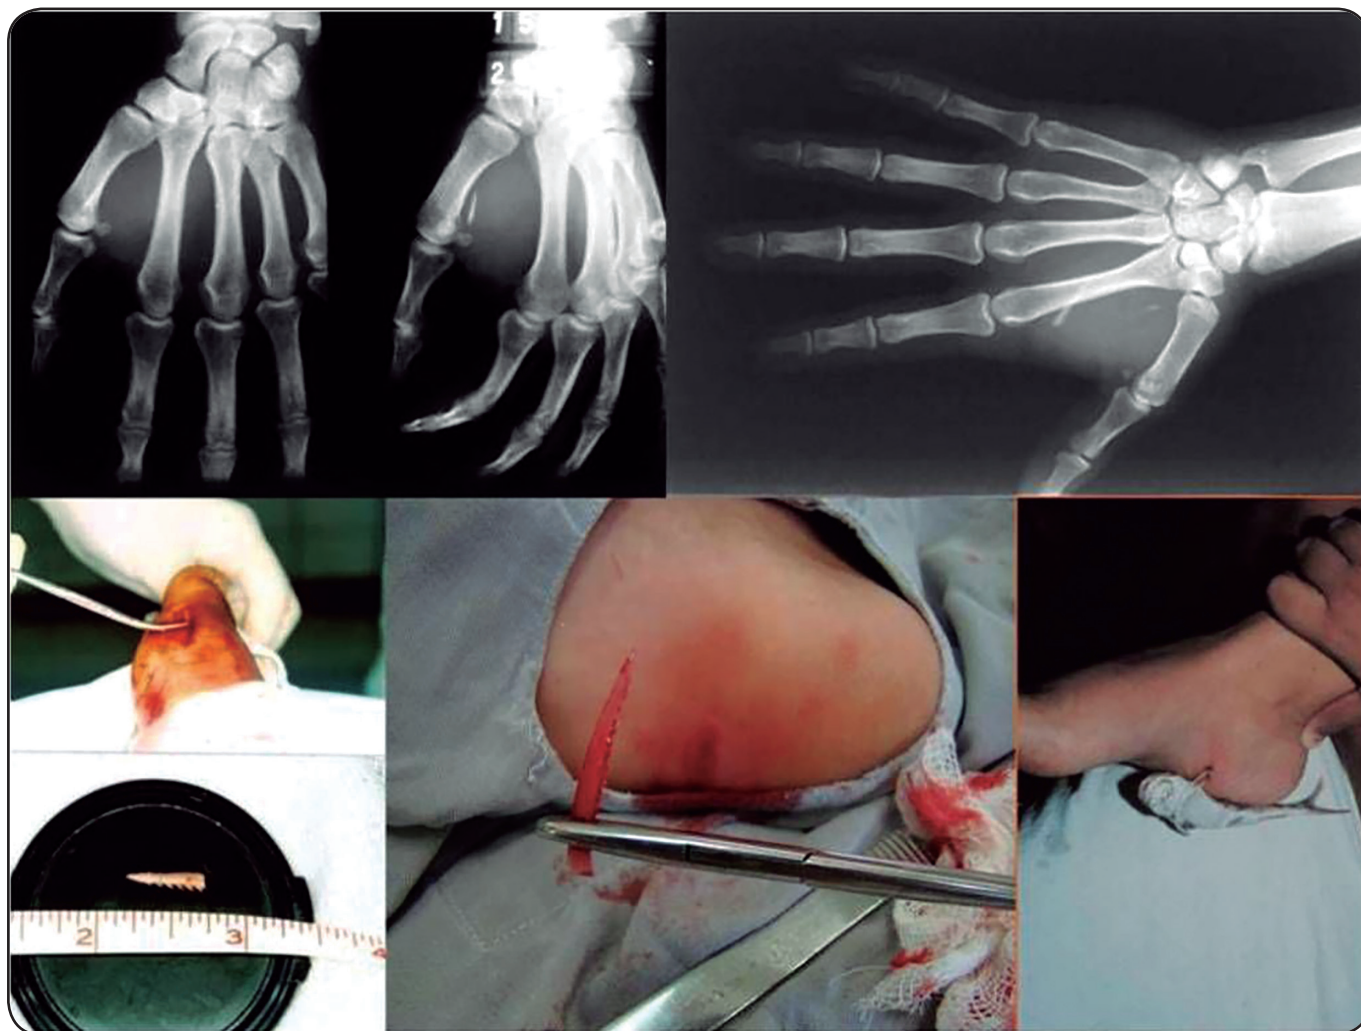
Conventional radiography of the hand showing embedded portions of the stinger near the first metacarpal bone that project over the second metacarpal bone. The breaking of stingers/barbs led to persisting inflammation and pain in the hands (Top). The only definitive treatment consisted of surgical removal of the fragments, The penetration of the sting is highly traumatic and the break in the wound is always possible. (Bottom).
